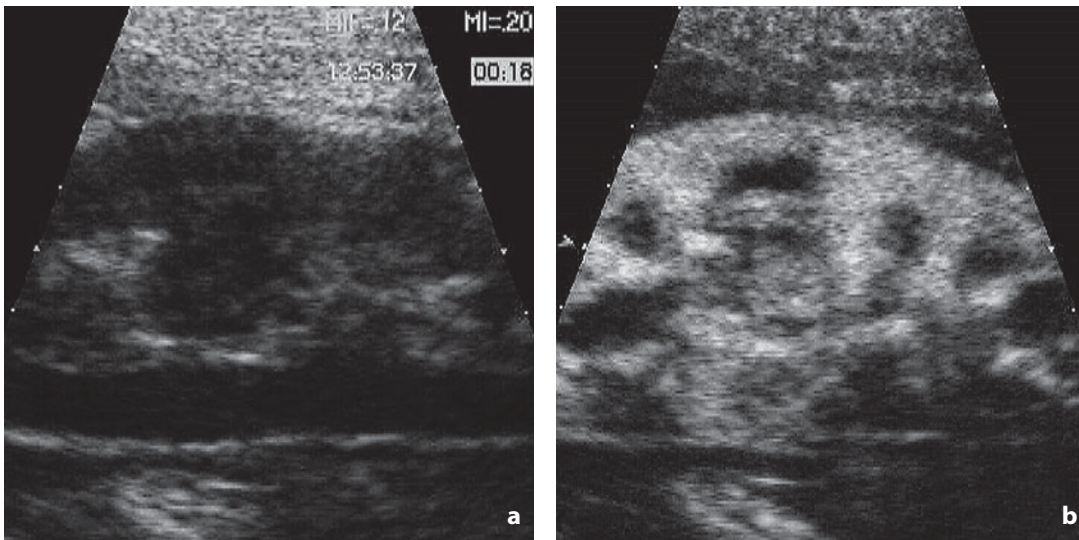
Ultrasonography, dynamic study with contrast medium. a Baseline sonogram. b Arterial or cortico-medullary phase. The typical intravascular distribution of the microbubbles of US contrast medium provides information on the vascularization of different parenchymal components. Since the blood supply is greater to the cortex than the medulla, the intense enhancement facilitates their differentiation
